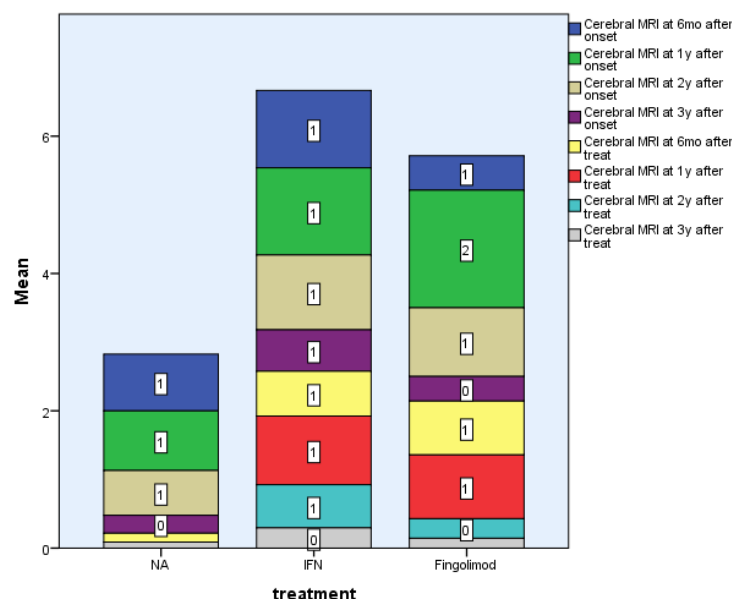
Cerebral MRI after diagnosis and treatment starts
